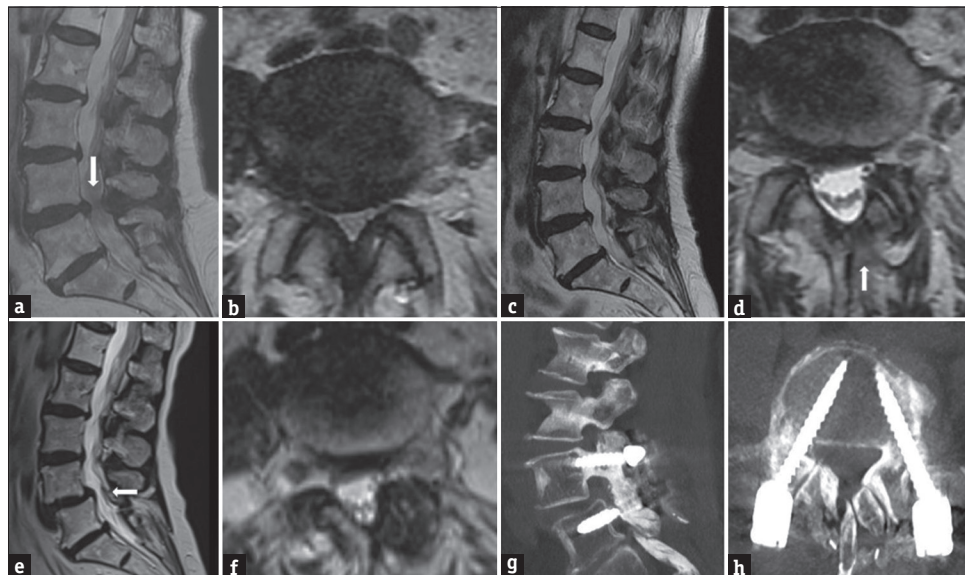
Sagittal and axial sections of lumbar MRI demonstrated L4-5 spinal stenosis (white arrow) (a and b). Sagittal and axial sections of lumbar MRI in postoperative period revealed decompression of dura mater at L4-5 vertebra level. White arrow shows left hemilaminectomy defect (c and d). Eighteen months after the first surgery, sagittal and axial sections demonstrated L4-5 listhesis (white arrow) (e) and lumbar stenosis (f) respectively. L4-5 posterior transpedicular screw placements were seen (g and h). MRI: Magnetic resonance imaging
